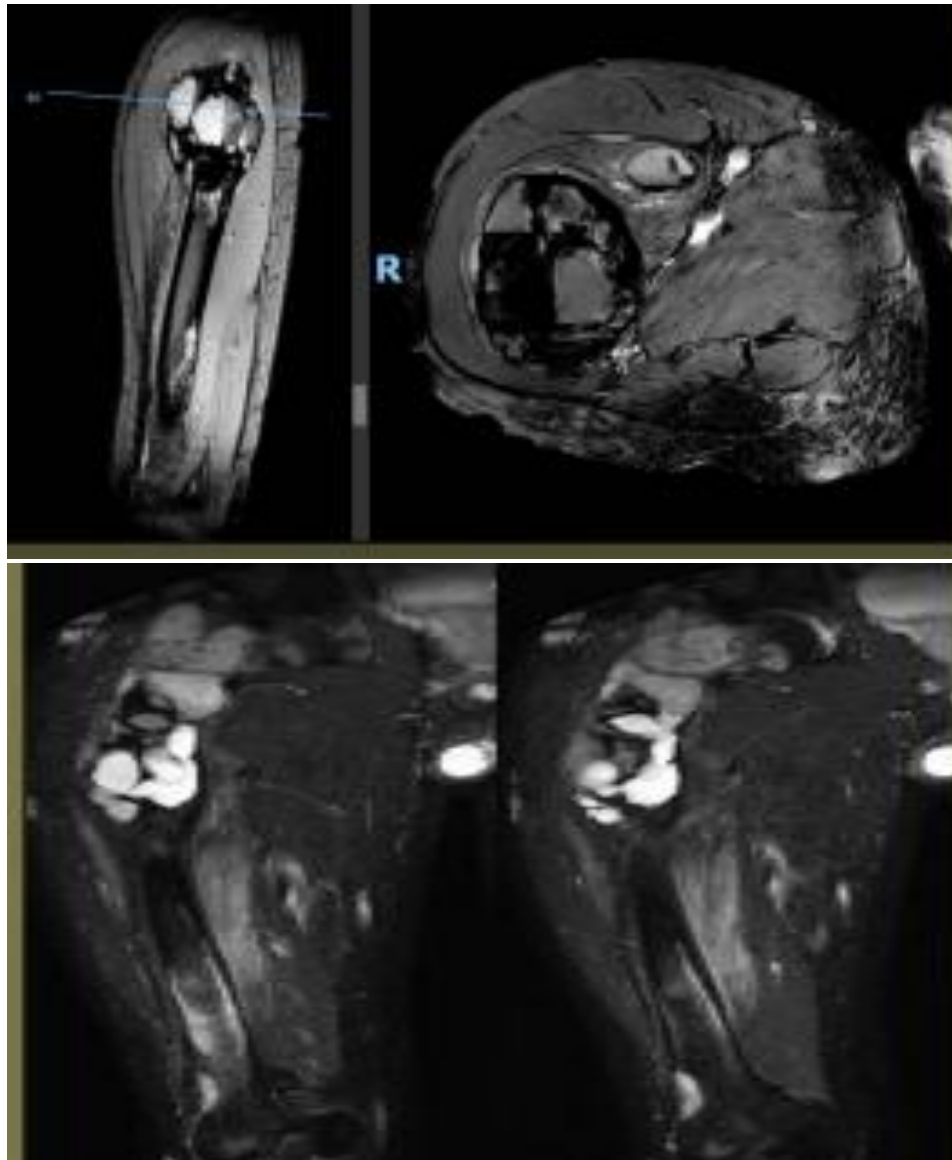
MRI of the right femur with contrast
